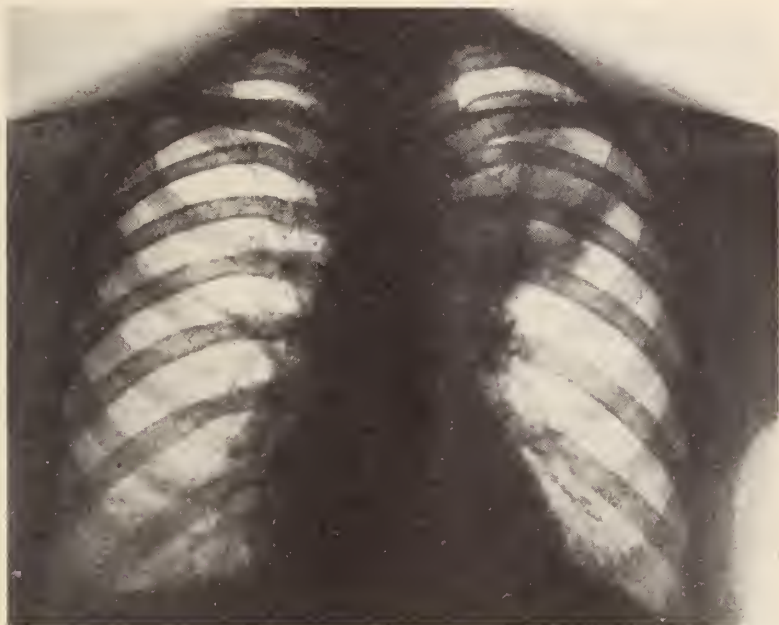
Roentgenogram taken November 28, 1932 showing abscess cavity in the left upper lobe.
